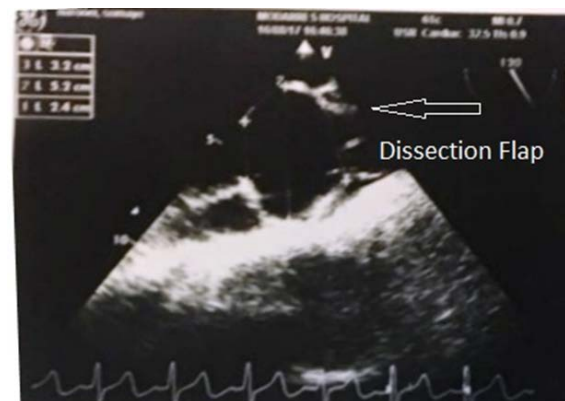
Transesophageal echocardiography mid esophageal ascending aorta long axis. The arrow shows the dissection flap of the ascending aorta.
